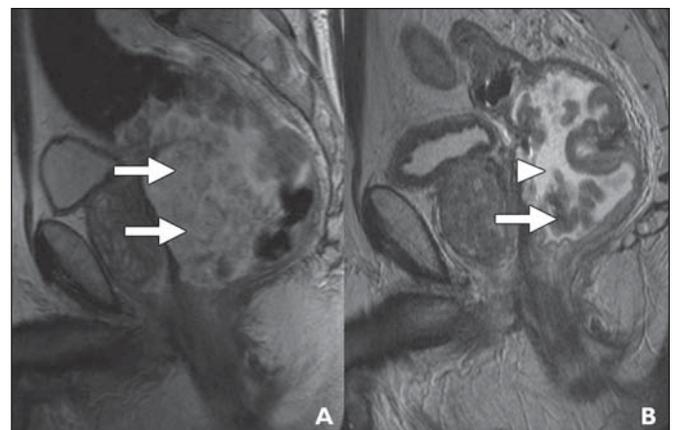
80-year-old man with rectal cancer. A, Baseline sagittal T2-weighted image shows large tumor with high signal intensity compatible with mucin. Intermediate-signal-intensity solid cellular components (arrows) are noted within tumor. B, Posttreatment sagittal T2-weighted image shows acellular mucin, indicated by featureless areas of high signal intensity (arrowhead), has formed since A. Areas of intermediate-signal-intensity residual tumor (arrow) remain.
